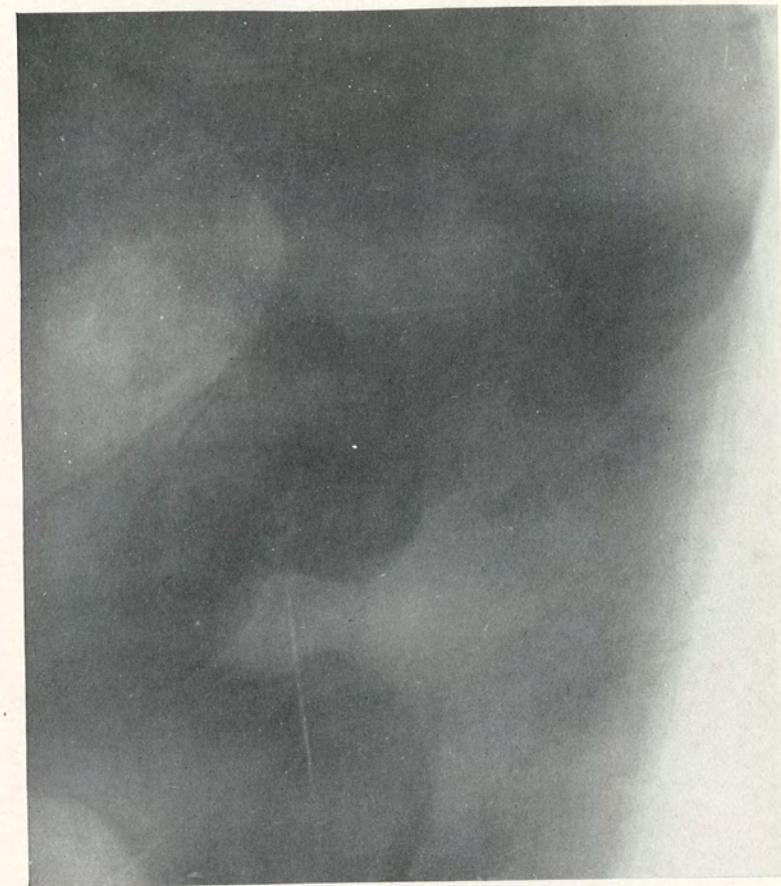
Case IX. X-ray No. 8722. Showing anterior dislocation of femur (right).
